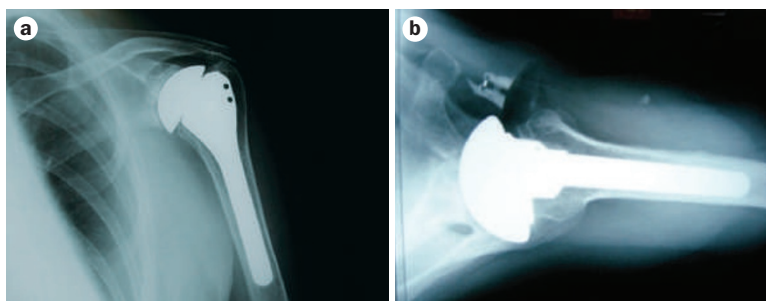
Shoulder replacement surgery for a patient with osteoarthritis of the shoulder joint. a | Radiograph of successful hemiarthroplasty showing that the relationship of the glenoid and humerus are well maintained. b | Radiograph of failed total shoulder replacement showing loosening and dislocation of the glenoid component.
